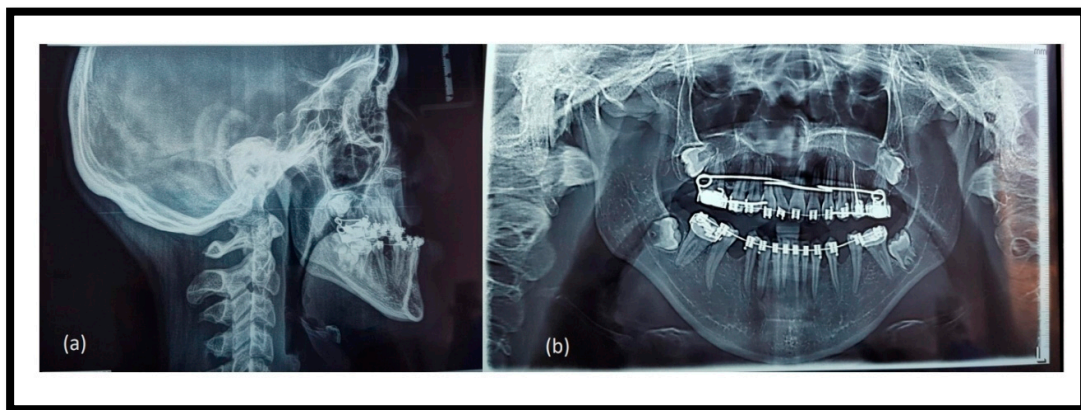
Before treatment radiographic imaging: (a) panoramic radiograph showing missing and unerupted teeth; (b) lateral cephalometric radiograph demonstrating retrognathic maxilla and skeletal class III malocclusion; (c) anteroposterior radiograph revealing mild facial asymmetry.
